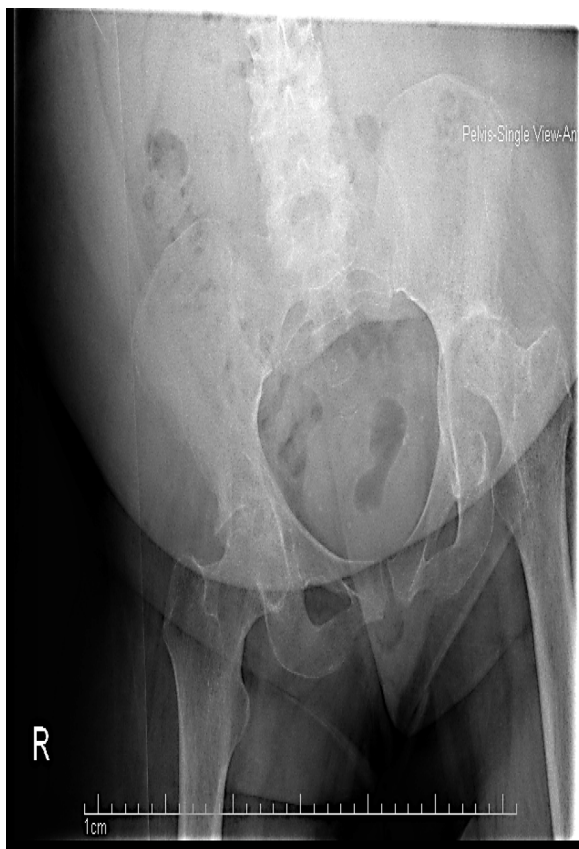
Single AP view Xray of the pelvis showing non visualization of the right and left femoral head attributed to resorption of the femoral neck. Marked subcondral sclerosis in the acetabulum bilaterally.
